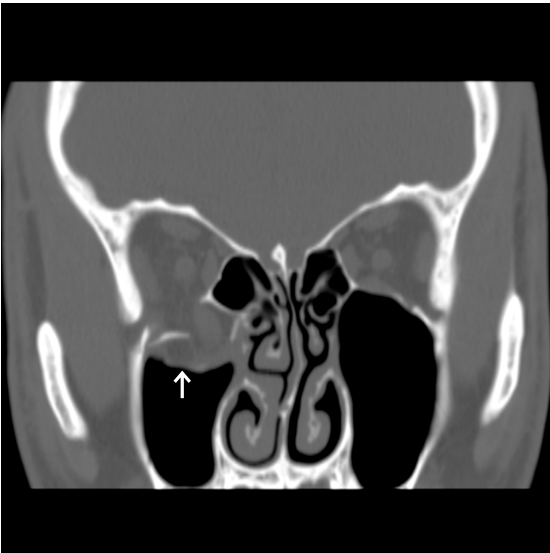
Coronal CT in bone window shows right blow out fracture (→).
